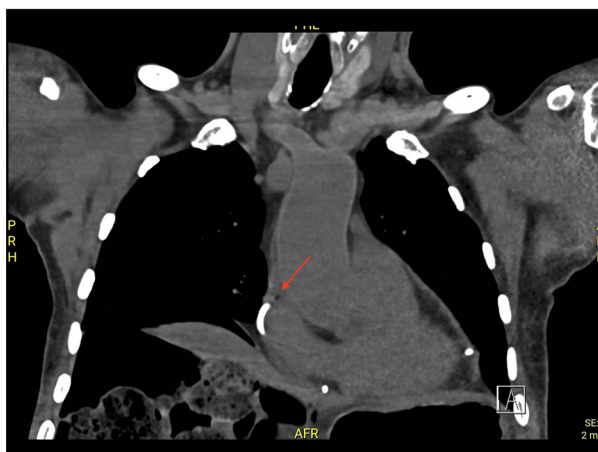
High resolution computed tomography showing pneumoperitoneum and tiny focus of pneumopericardium near pericardial drain tip (red arrow).
